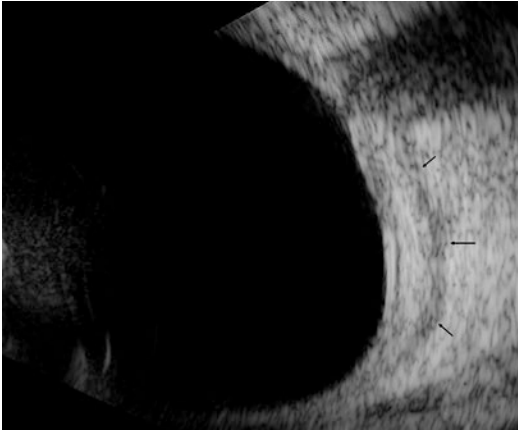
Ultrasound B-scan showing fluid in the sub-tenon's space (*black arrows*) adjacent to the optic disc
